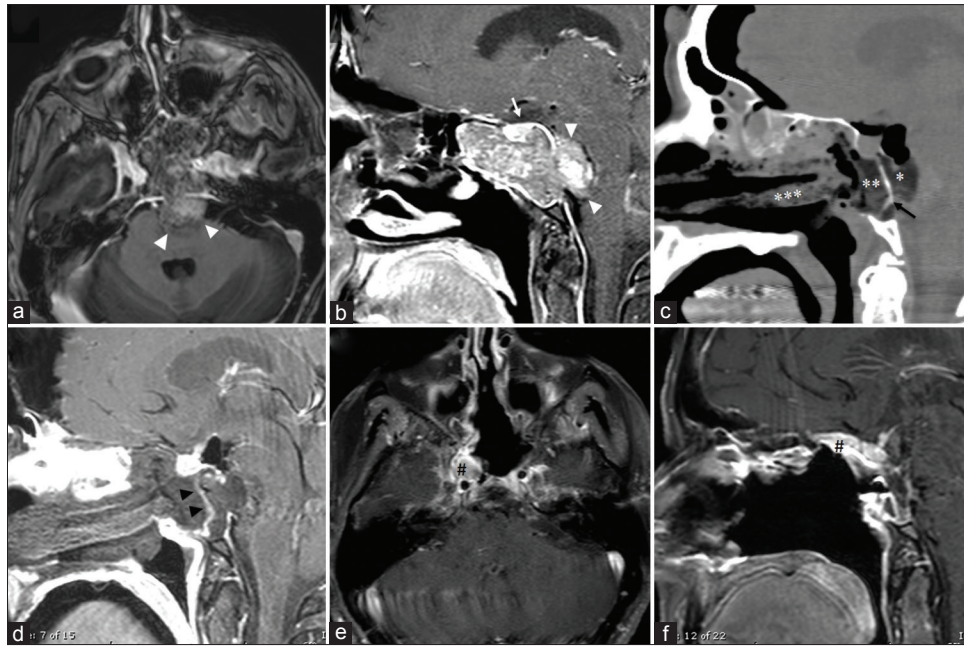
A 61-year-old female who presented with headaches. Her MRI with gadolinium (a and b) revealed a sphenoclivial mass with preservation of sellar contents (white arrow) and intradural invasion and compression of the brain stem (white arrowheads). The patient underwent a transsphenoidal, transclival EEA for resection of the tumor. The pathology was consistent with chordoma. A postoperative CT (c) was completed immediately after surgery to assure no dislodgment of her multilayered skull base reconstruction with intradural fat graft (*), bone (black arrow), extradural fat graft (), and right nasoseptal flap, which were buttressed with Merocel packs (*). Fat suppression T1 MRI with gadolinium was completed on postoperative day 1 (d) with clear enhancement of the nasoseptal flap (black arrowheads). Her fat suppression MRI with gadolinium 3 months after surgery (e and f) demonstrate no definitive tumor enhancement. The enhancement along the right posterior and superior nasal cavity (#) is consistent with the right nasoseptal flap enhancement
